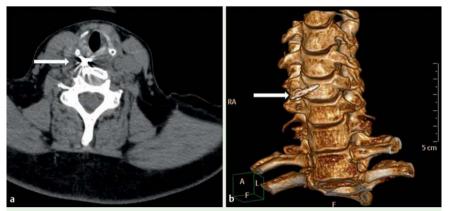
a Computed tomography shows a metallic foreign body in the right pharyngeal cavity (white arrow) of a 66-year-old woman with symptoms of foreign-body sensation and pharyngeal pain after the accidental ingestion of a foreign body during breakfast. b Three-dimensional imaging shows the foreign body located at the level of the fifth cervical vertebra (white arrow).
